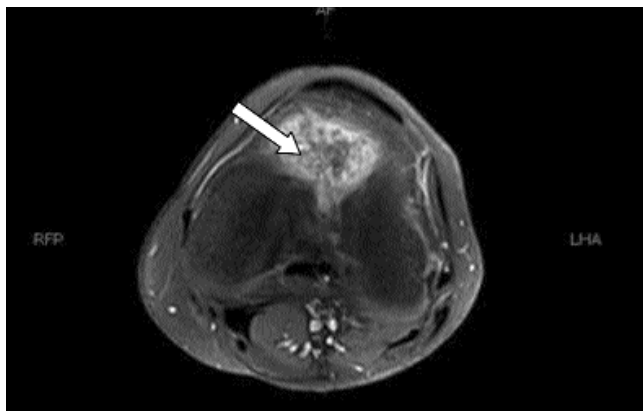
Magnetic resonance imaging (MRI) of the left knee with contrast showing irregular abnormal intensity lesion (white arrow) anterior to the lower end of femoral condyle in the intercondylar notch just below the level of patella showing significant post-contrast enhancement.
